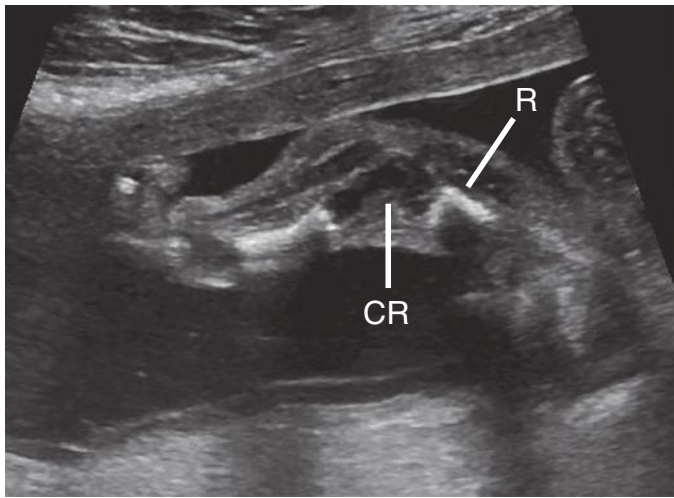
Sonogram of a 25-week fetal wrist. CR, cartilaginous carpal bones; R, radial diaphysis (distal radial epiphysis is also cartilaginous).
